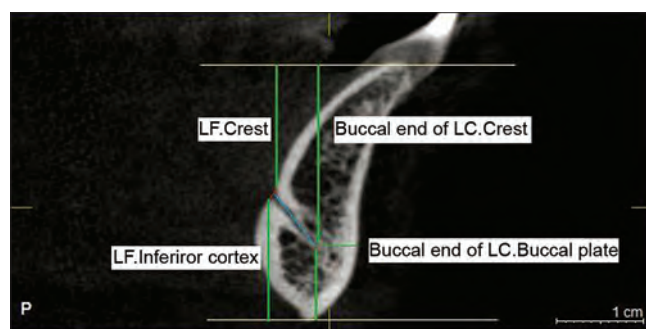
Dimensional measurements on a reformatted cross-sectional image of mandibular CBCT
